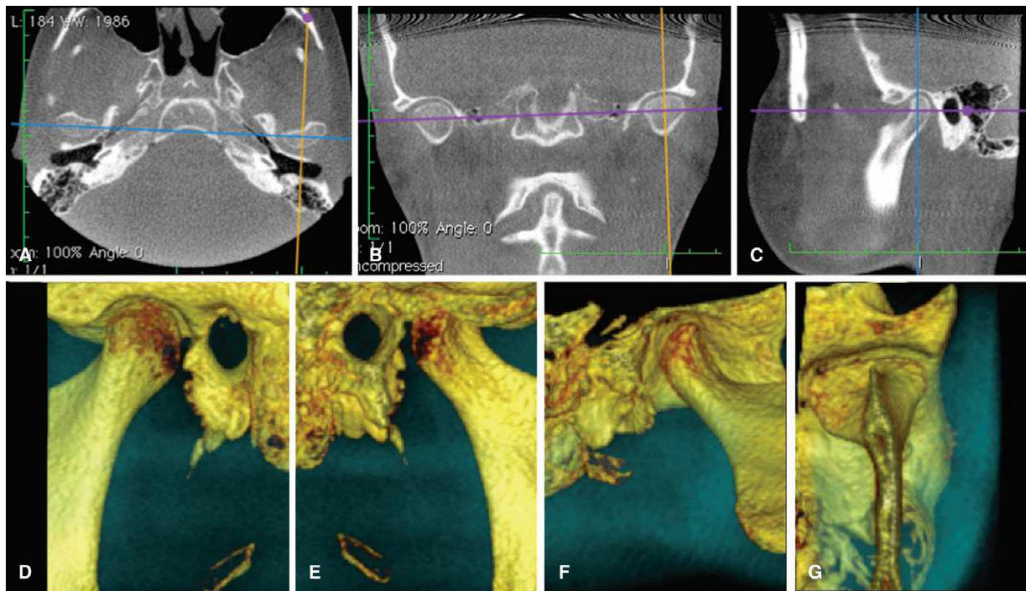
CBCT images of TMJ disorders
